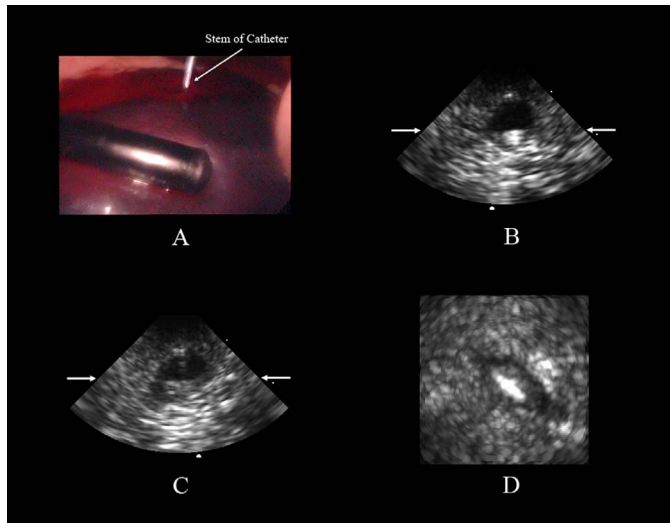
Simultaneous optical laparoscope view (A) and 3-D laparoscopic ultrasound of the spleen. A hypoechoic imaging target introduced in the spleen is seen in short axis cross section in the B-scans (B and C). The long-axis profile with the central spine of the target is visible in the C-scan (D).
